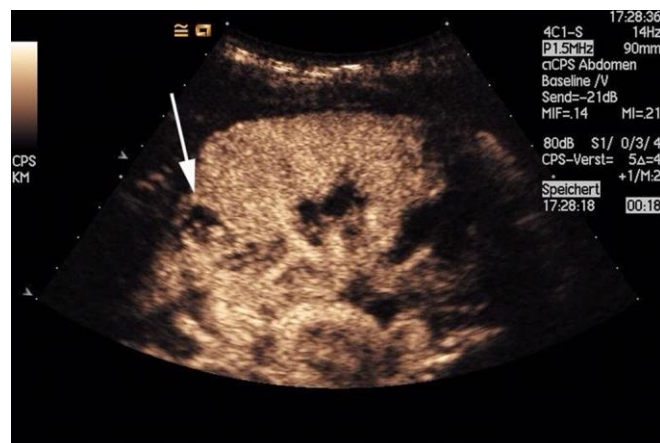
Patient with acute lobar pyelonephritis on an upper pole (a). Contrast-enhanced ultrasound (CEUS) in the same patient shows a visible perfusion defect 18s after contrast injection, which is typical for acute pyelonephritis (b).
